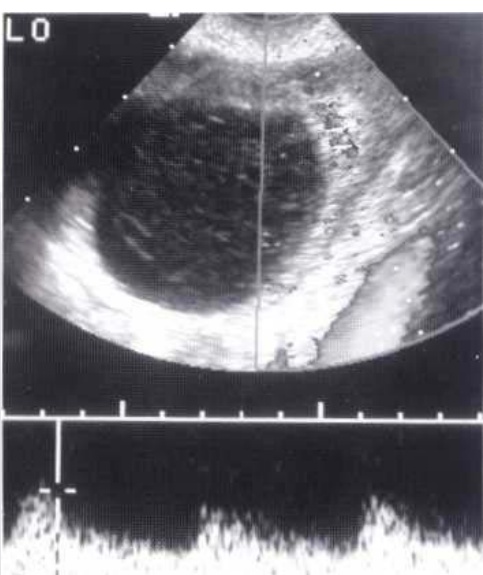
Corpus luteum. Spectral Doppler shows low impedance flow with RI of 0.57.
